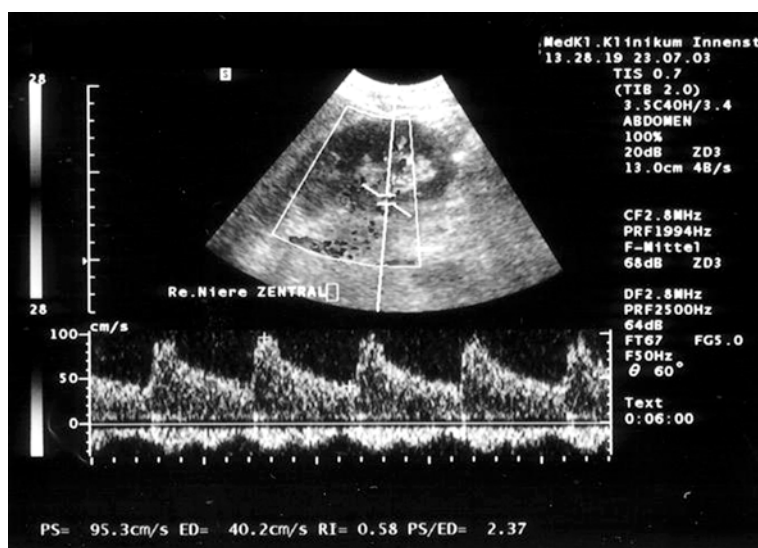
Doppler ultrasonographic measurement of RI in intrarenal interlobar arteries. Figure 1 shows a normal value of 0.58 in a healthy adult (25 years old).
